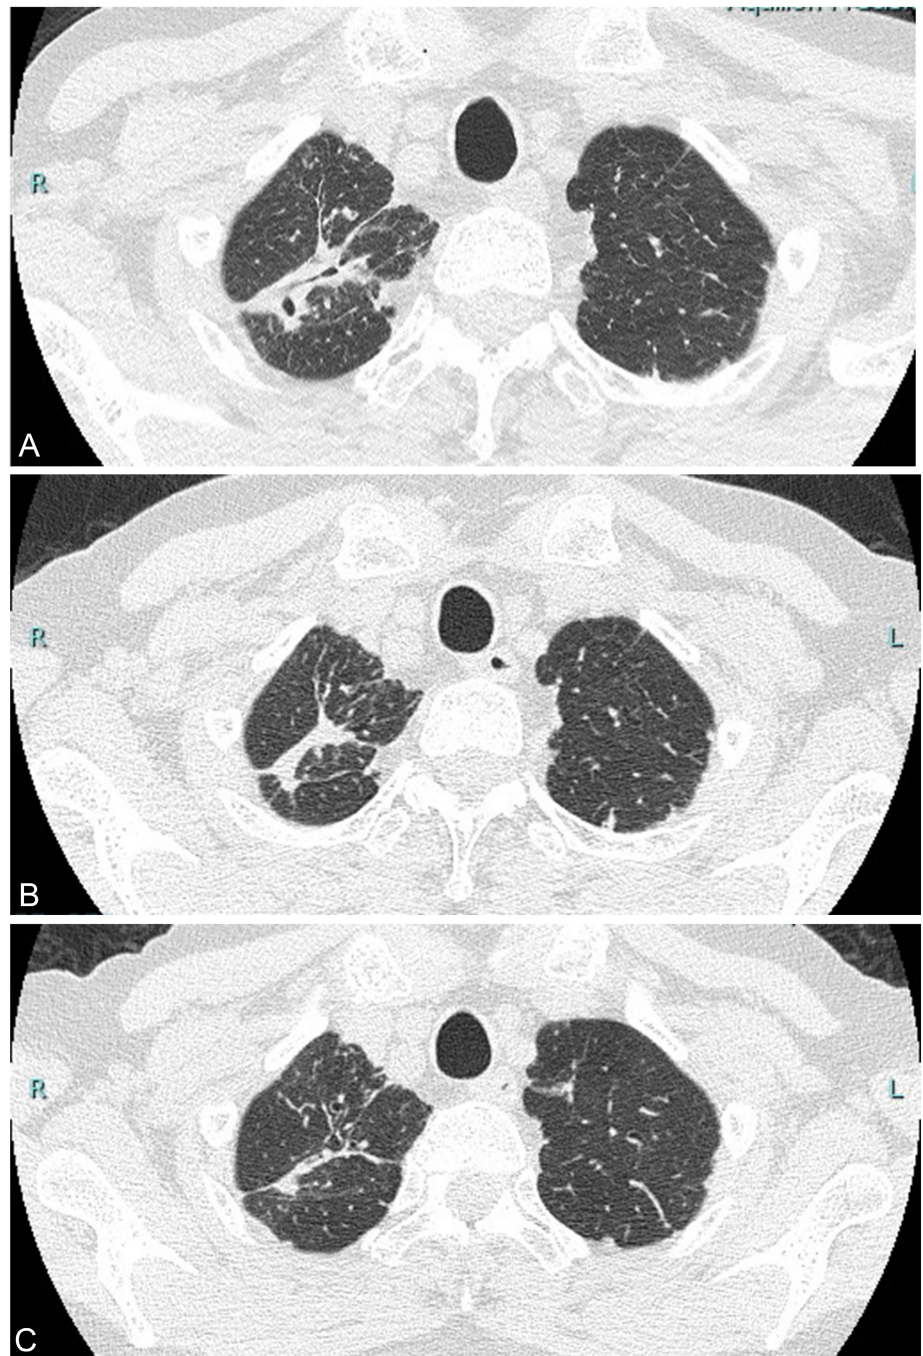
A: Pulmonary mass in the right upper lobe on computed tomography (CT) before avacopan administration. B: Pulmonary mass in the right upper lobe on CT 12 months after avacopan administration. C: Further regression of the pulmonary mass in the right upper lobe on CT 20 months after avacopan administration.
